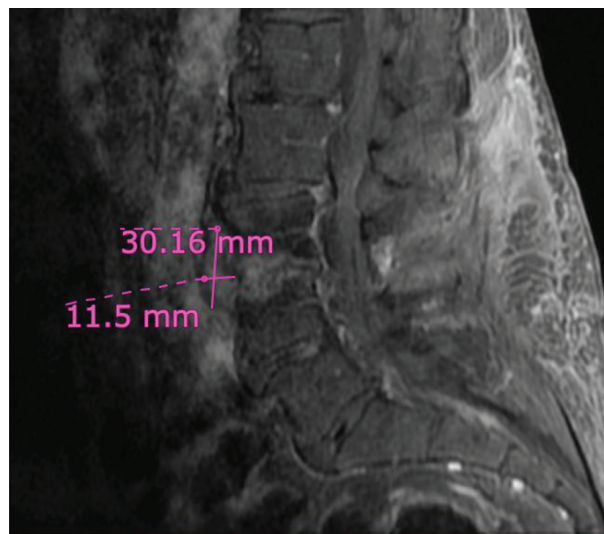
MRI showing persistent endplate changes. MRI, magnetic resonance imaging.
